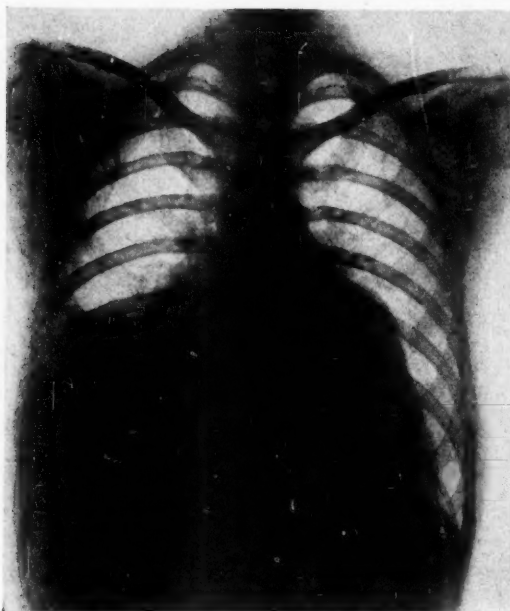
Roentgenogram made after clinical manifestations of pulmonary infarction. Note convex density of the right lower lung field the upper margin of which presents the typical Ellis Line of a hydrothorax. Fluid at this time was serosanguineous and sterile on culture.
